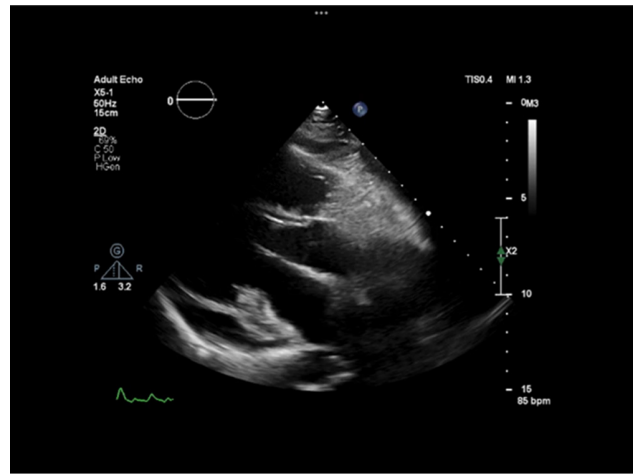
Transthoracic Echocardiography Showed no Rheumatismal Changes in the Mitral Leaflets.
